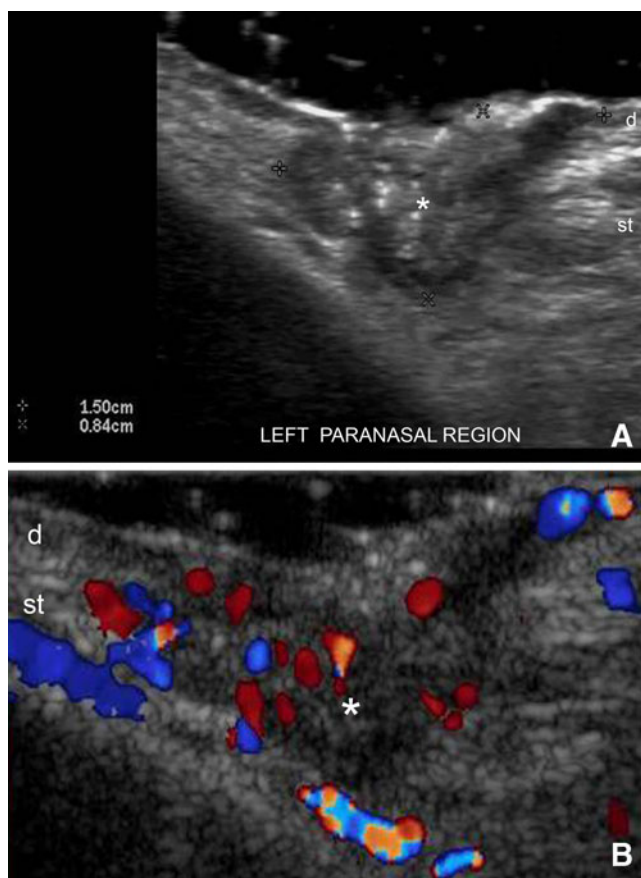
(A, B) Basal cell carcinoma. A Ultrasound (transverse view) shows a hypoechoic tumoral lesion (*asterisk*) with irregular and lobulated borders affecting the dermis and subcutaneous tissue. Hyperechoic dots (*white*) are visible within the tumoral tissue. B Color Doppler ultrasound (transverse axis) shows increased blood flow within the tumor (*asterisk*). Abbreviations: *d* dermis, *st* subcutaneous tissue
